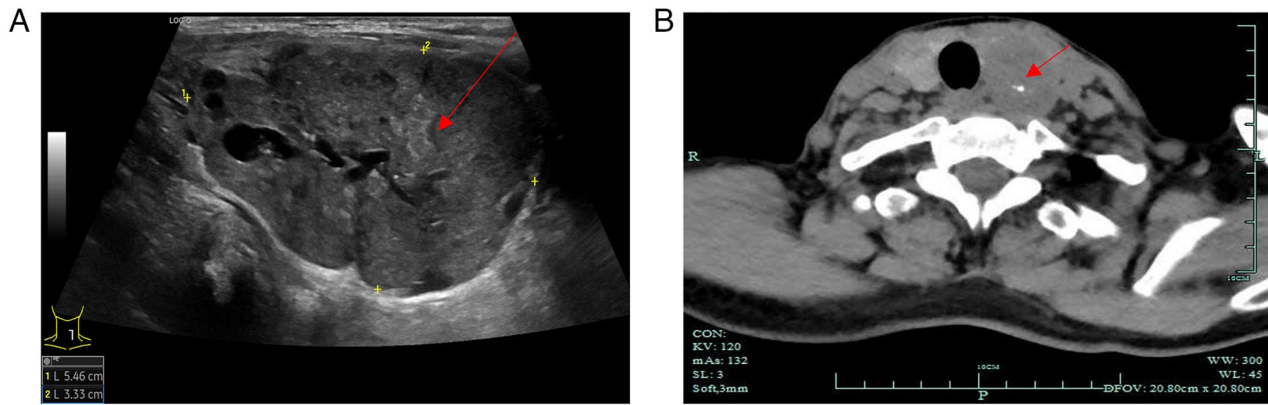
Ultrasound and computed tomography imaging of the thyroid. (A) Ultrasonography revealed a well-defined, hypoechoic mass (red arrow) with microcalcification, measuring 55x41x33 mm in the left lobe of the thyroid gland. (B) Computed tomography demonstrated that the left lobe of the thyroid gland was enlarged, with a mass-like area of low density (red arrow), measuring ~40x32 mm. Tumor density was heterogeneous with visible calcifications.
